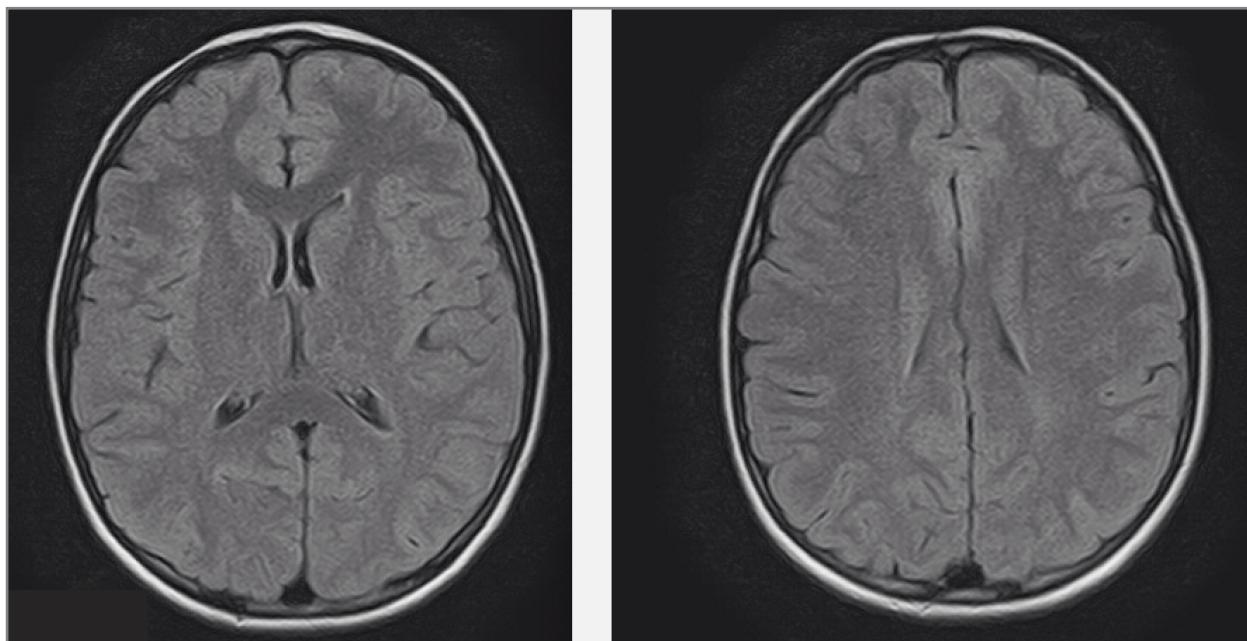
T2 Flair MRI images showing no lesions at 10-years follow-up
